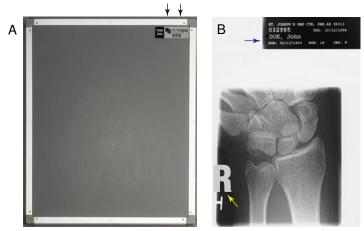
A, Film cassette with patient information in block (*arrows*). B, Radiograph (*blue arrow*, Patient identification information; *yellow arrow*, Anatomic side marker to indicate right wrist).
